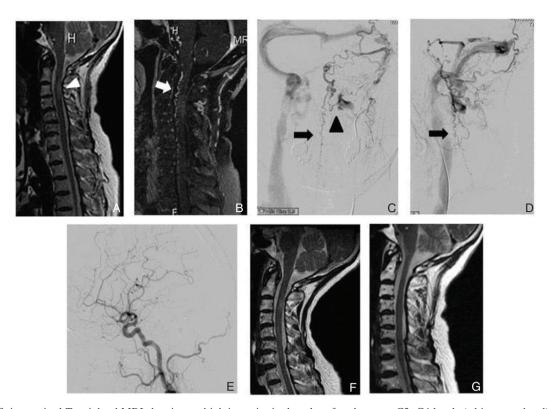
A: Spine sagittal T_2 -wighted MRI showing an high intensity in dorsal surface between C2–C4 levels (white arrowhead). B: Sagittal gadolinium-enhanced cervical MRI shows the perimedullary vein (white arrow). C, D: Left external carotid angiograms, anteroposterior (C) and lateral (D) views, shows a left tranverse-sigmoid sinus dural arteriovenous fistula supplied by the left middle meningeal artery and occipital artery. Venous drainage is contralateral transverse sinus and anterior spinal perimedullary vein through superior petrosal sinus (black arrow). Other drainage route in C-2 level is internal vertebral venous plexus and radiculospinal vein through radiculomedullary vein (black arrowhead). E: Left common carotid angiogram (lateral view) after embolization shows no contrast filling of the dural arteriovenous fistula. F: 1 month after embolization, T_2 -weighted MRI of cervical spinal cord showed the cervical high intensity region was improved gradually. G: Cervical high intensity region was disappeared 1 year after embolization. MRI: magnetic resonance imaging.
